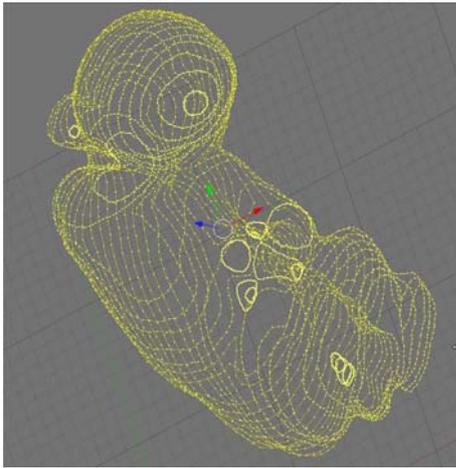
Set of 2D fetus contours, extracted from an MRI data set, after Gaussian smoothing
